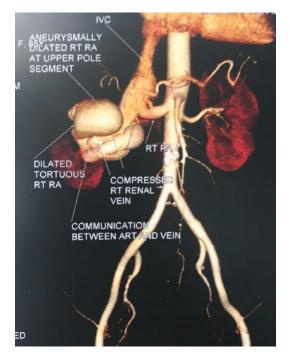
CT angiography shows right Renal AVM with aneurysm
